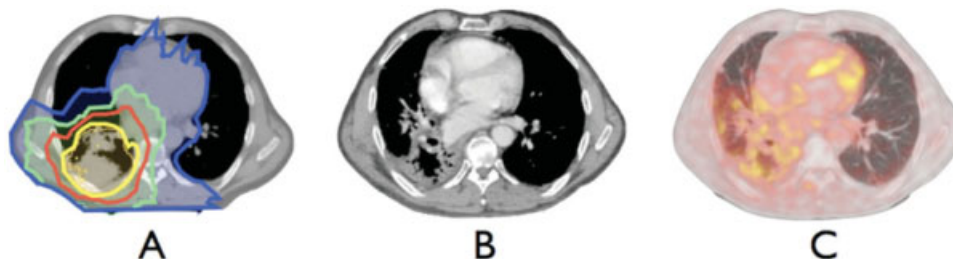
Dose distribution on (A) the planning computed tomography (CT) scan (blue line, 20 grays [Gy]; green line, 30 Gy; red line, 50 Gy; yellow line, 95% of the prescribed target dose) from a patient who died of a radiopneumonitis observed on (B) the CT scan 3 months after treatment with an increased metabolism (C) in the high-dose region on the corresponding F18-fluorodeoxyglucose-positron emission tomography image.
